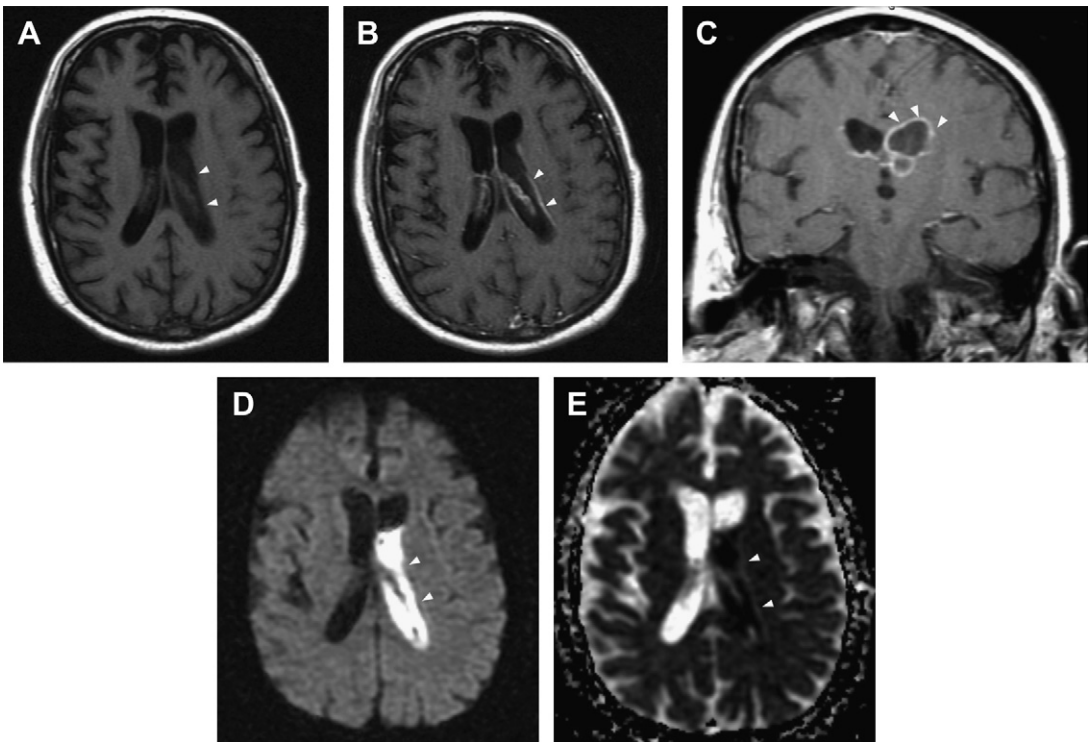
Bacterial ventriculitis. (A) Axial T1WI shows subtle increased signal within the left lateral ventricle, indicating debris. (B, C) Axial and coronal T1WI after contrast shows increased ependymal enhancement along the left lateral ventricle consistent with ventriculitis. (D, E) DWI and corresponding ADC map show restricted diffusion within the left lateral ventricle, suggestive of abscess formation.
